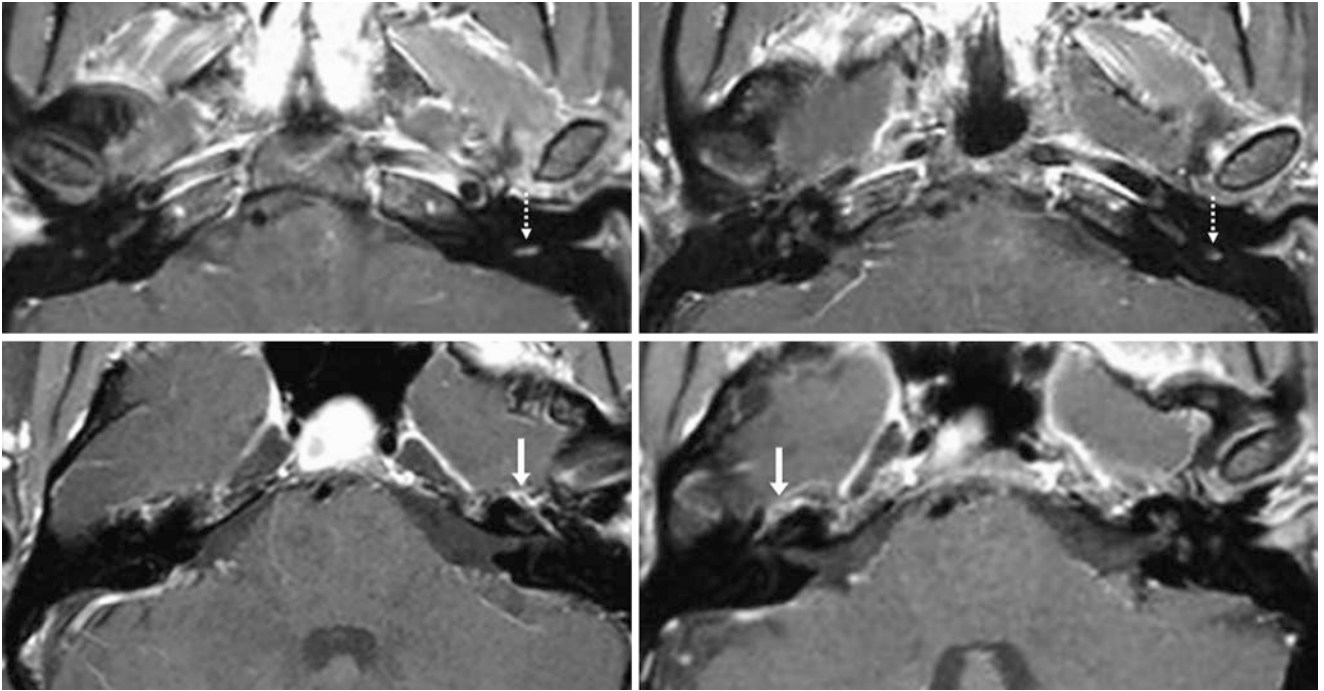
A 31-year-old patient with a negative 3 T MRI for facial pain. There is asymmetric enhancement of only the left descending CN7 segment (*dotted arrows*) on axial FS SET1WIs (*top row*); the fat
